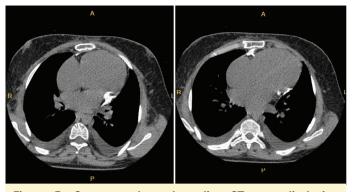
Contrast-enhanced cardiac CT scan displaying residual calcified constrictive pericardium attached to the posterior left atrium, extending to the posterior left ventricle.
